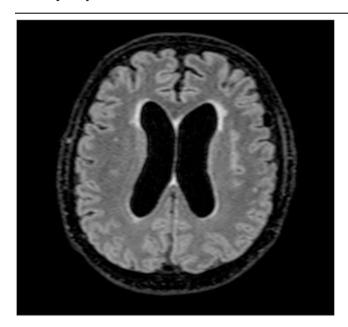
Axial FLAIR (Fluid attenuated inversion recovery) demonstrating mild hydrocephalus, with enlargement of the lateral ventricles. The leptomeningeal infiltrate may result in obstructed cerebrospinal fluid (CSF) flow.
